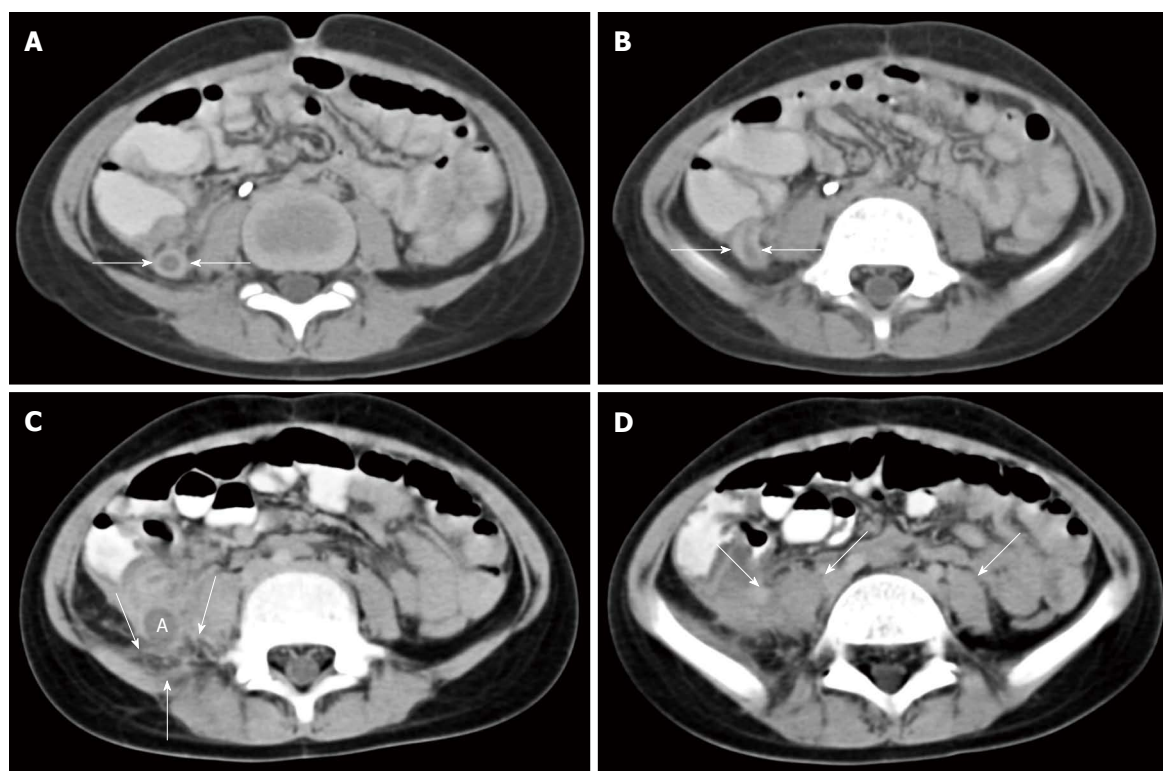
Computed tomography images. Computed tomography images of abdomen using IV non-ionic contrast and standard oral contrast demonstrates dilated appendiceal ostium and thickened appendiceal wall in cross-section (arrows in A); dilated lumen and thickened wall of vermiform appendix in longitudinal section (arrows in B); periappendiceal fat stranding (arrows in C) and an enlarged right psoas muscle with indistinct margins from local extension of the appendiceal inflammation (enlarged right psoas muscle with indistinct margins identified in D by 2 arrows, as compared to normal-sized left psoas muscle with distinct margins identified by 1 arrow). The appendix measures approximately 11 mm in diameter from outer wall to outer wall. All these findings are consistent with acute appendicitis. There is no evident appendicolith or typhlitis.
